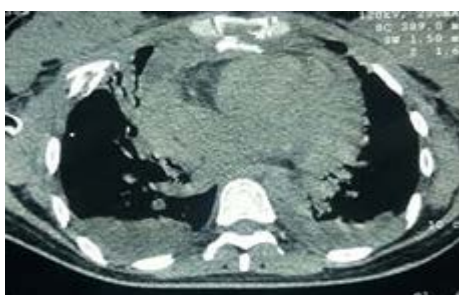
Axial view of computed tomography scan of the patient's chest showing bilateral hemothorax
